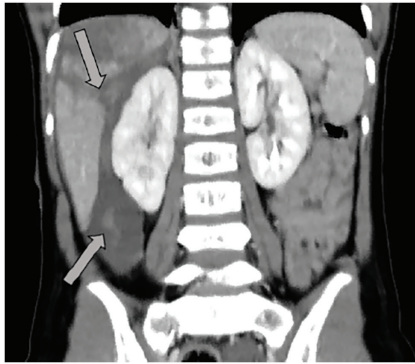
CE-CT on day 1. The coronal view shows the injury was mainly focused on the right posterior segment with disruption of the liver capsule, extensive hemoperitoneum, and contrast extravasation (arrows).
